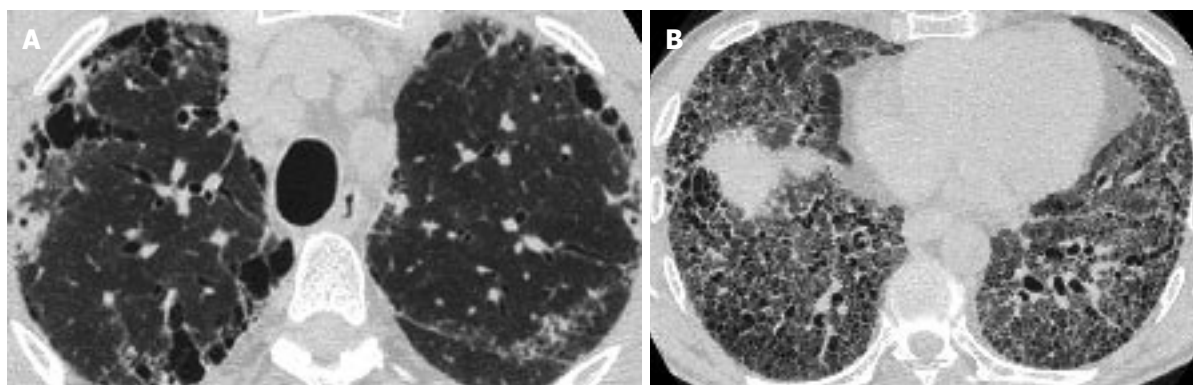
Paraseptal emphysema and usual interstitial pneumonia-pattern of pulmonary fibrosis. A: High resolution computed tomography (HRCT) at the level of the upper lobes shows paraseptal emphysema associated with subpleural reticular pattern and minimal ground glass opacity; B: HRCT of the same patient as in A, at the level of the lower lobes reveals extensive coarse reticular pattern characterized by traction bronchiectasis associated with ground glass opacity and subpleural honeycombing. The HRCT pattern is consistent more with usual interstitial pneumonia.
